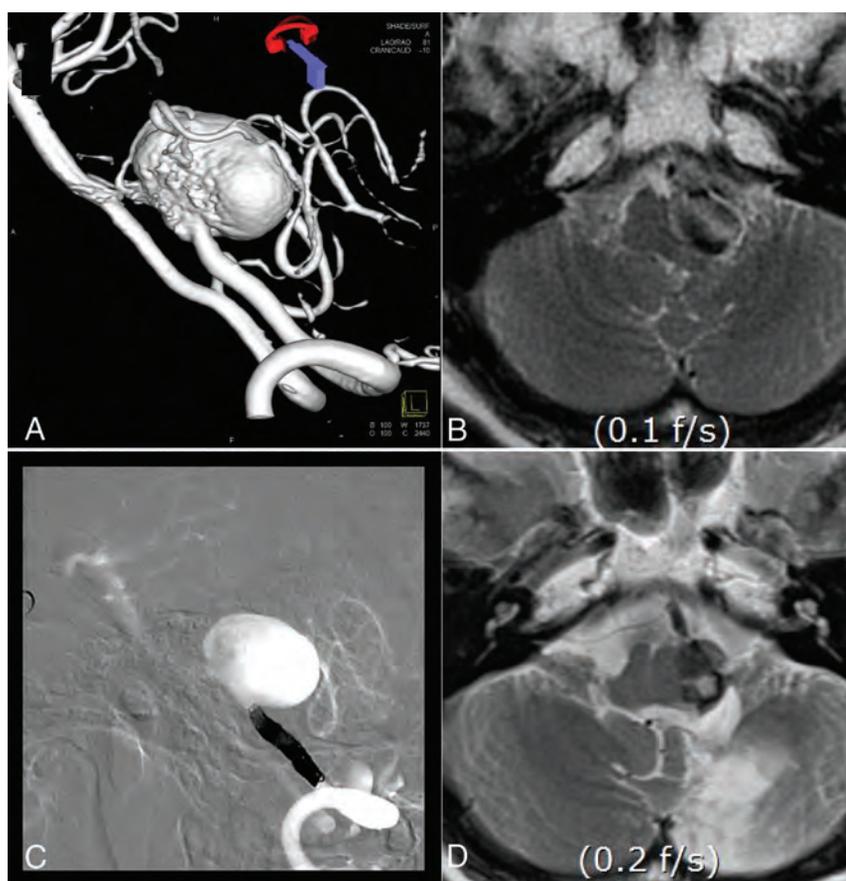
Reduction of vertebral artery dissecting aneurysm size using PAO in 58-year-old woman. A, Rotational 3D angiography shows a large vertebral artery dissecting aneurysm in the fourth segment of the left vertebral artery. B, T2 axial MR image shows thrombus formation with brain stem compression. C, PAO was performed. D, T2 axial MR imaging after 12 months shows a decreased diameter of the aneurysm with diminished brain stem compression.
